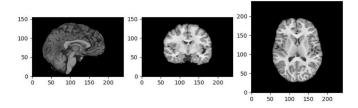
MRI 3D Image Slices along X, Y and Z Axes
